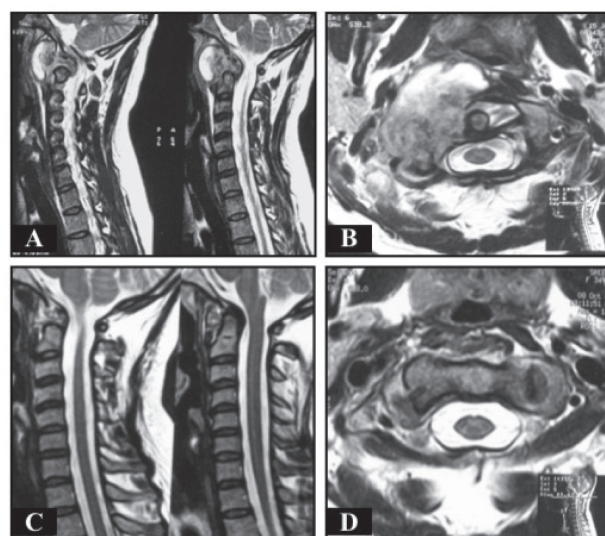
Showing the MRI of grade 2 patient. A&B: pre treatment images of sagittal and axial images showing destruction of right atlanto axial joint and paraspinal collection causing the thecal sac compression. C&D: sagittal and axial images showing complete resolution of the disease with medical management.
